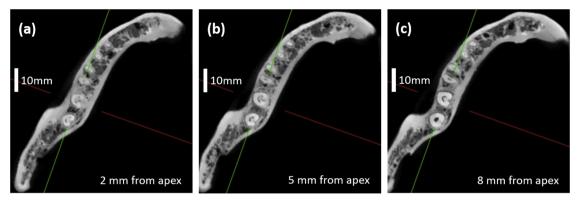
Example of cone beam computed tomography axial images of a tooth with a C-shaped canal configuration. (a) 2 mm from apical level; (b) 5 mm from apical level; (c) 8 mm from apical level.
